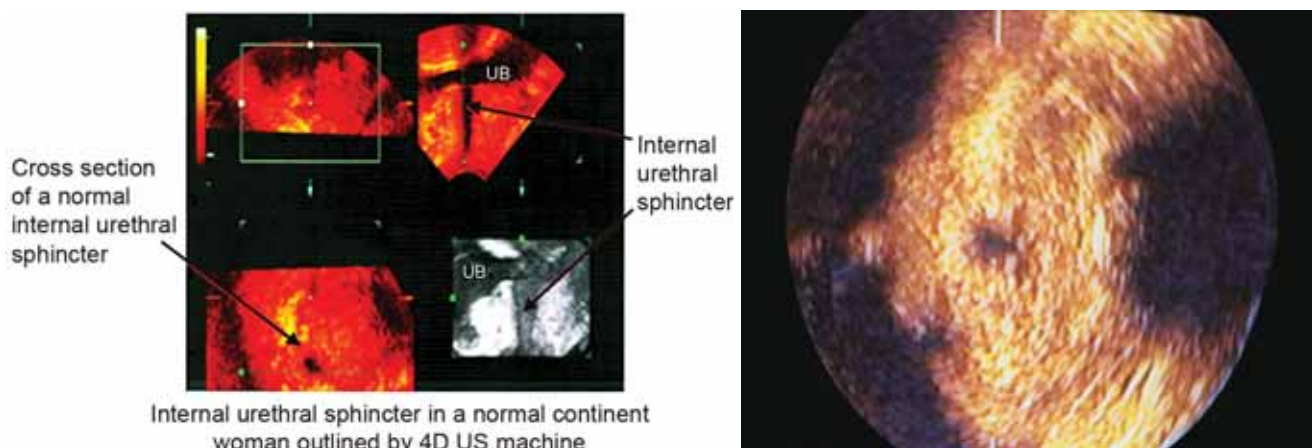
Ultrasound scanning by 3-4D US of normal continent women showing the IUS as a compact tissue cylinder; in the cross section on the right, kindly notice two echoes (muscle on top of collagen and collagen alone) and a closed urethral lumen
